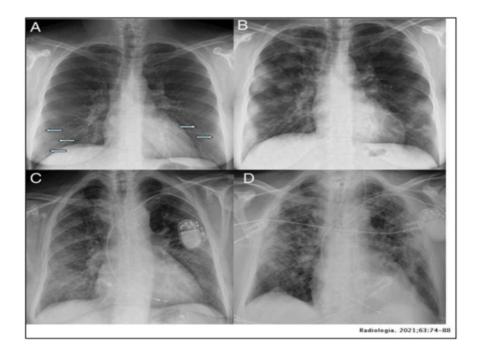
Lung X-ray of COVID-19 patient A, Bilateral peripheral mid and lower air spaces B, Peripheral bilateral opacities C, Paches of consolidation D, Bilateral air space consolidation (Jacobi et al., 2020).
